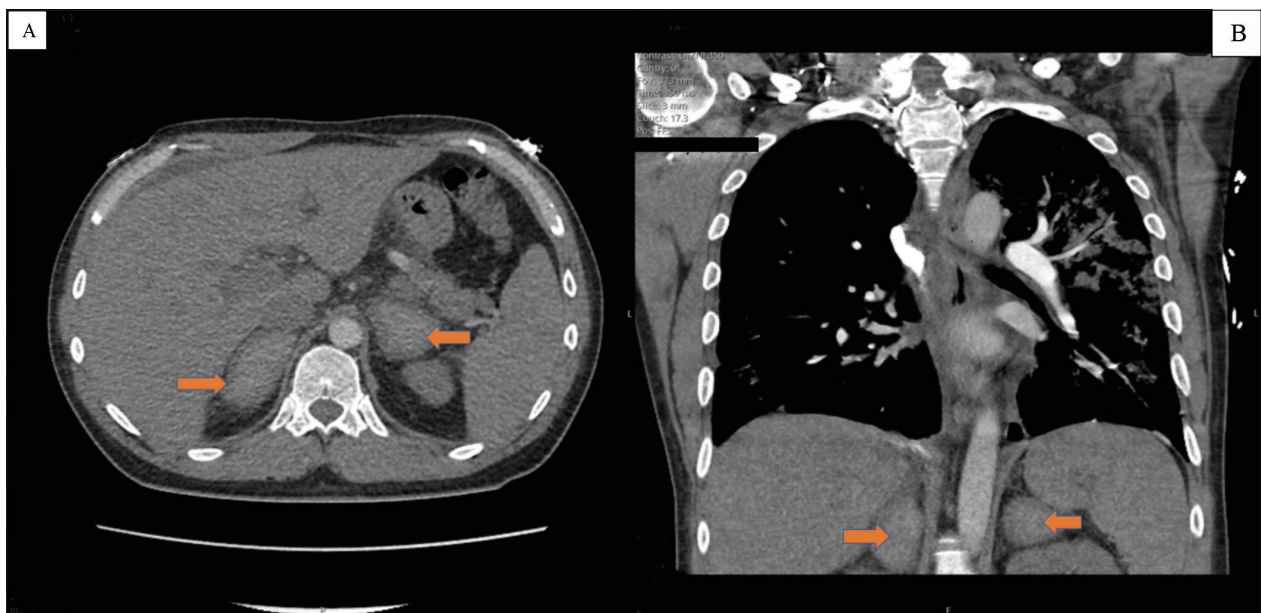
Computed tomography angiography chest axial view (A) and coronal view, orange arrows show hyperdense, masslike bilateral adrenal glands (B).
